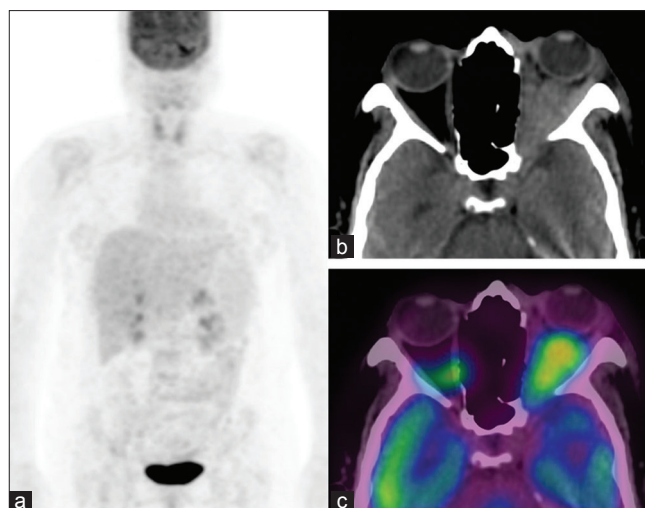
Bilateral retinoblastoma: A 7-year-old boy presented with bilateral orbital swelling and was diagnosed with bilateral retinoblastoma. Maximum intensity projection image (a) of the fluorodeoxyglucose positron emission tomography/computed tomography scan shows focal uptake in multiple sites in skeletal system (arrow) apart from the uptake in both the orbital region. Note the calcification (block arrow) of the ocular masses in the axial images (b and c) which is characteristic of retinoblastoma. Coronal fusion (d) and computed tomography image (e) shows metastases to right humerus
